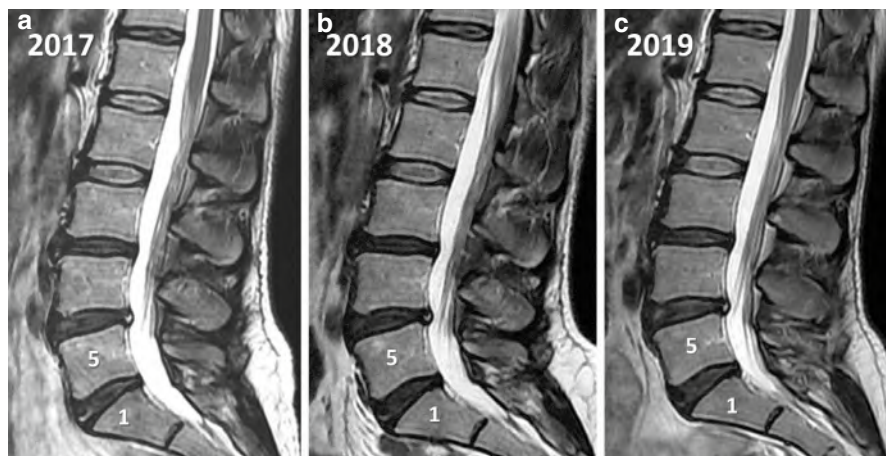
Serial sagittal T2-weighted MRI of the lumbar spine following intradiscal bone marrow aspirate concentrate (BMAC) injection. (a) Sagittal T2-weighted MRI demonstrates multilevel degenerative disc disease involving L3–L4, L4–L5, and L5–S1. The L5–S1 disc, which was clinically symptomatic, shows reduced disc height and an anterior annular fissure. (b) Follow-up sagittal T2-weighted MRI obtained approximately 1 year after intradiscal BMAC injection at L5–S1 demonstrates a mild interval increase in disc height, with decreased conspicuity of the anterior annular fissure. The patient reported interval improvement in low back pain. (c) Follow-up sagittal T2-weighted MRI obtained approximately 2 years after intradiscal BMAC injection demonstrates a further mild increase in L5–S1 disc height, with the anterior annular fissure now minimally perceptible. The patient reported sustained clinical improvement with improved functional status
